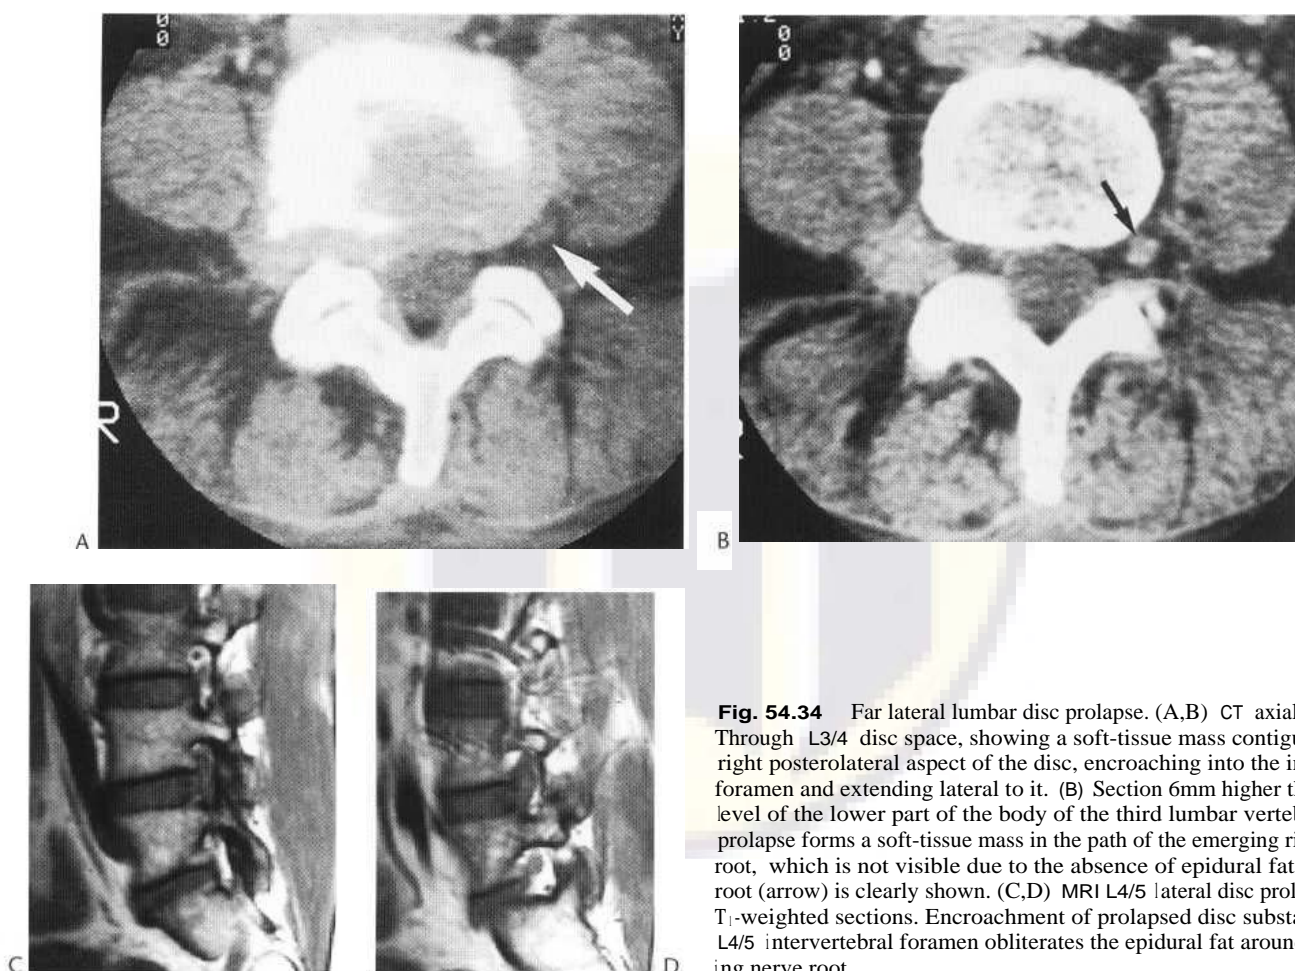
Far lateral lumbar disc prolapse. (A,B) CT axial sections. (A) Through L3/4 disc space, showing a soft-tissue mass contiguous with the right posterolateral aspect of the disc, encroaching into the intervertebral foramen and extending lateral to it. (B) Section 6mm higher than A, and at level of the lower part of the body of the third lumbar vertebra. The disc prolapse forms a soft-tissue mass in the path of the emerging right L3 nerve root, which is not visible due to the absence of epidural fat. The left L3 root (arrow) is clearly shown. (C,D) MRI L4/5 lateral disc prolapse. Sagittal T₁-weighted sections. Encroachment of prolapsed disc substance into the L4/5 intervertebral foramen obliterates the epidural fat around the emerging nerve root.
